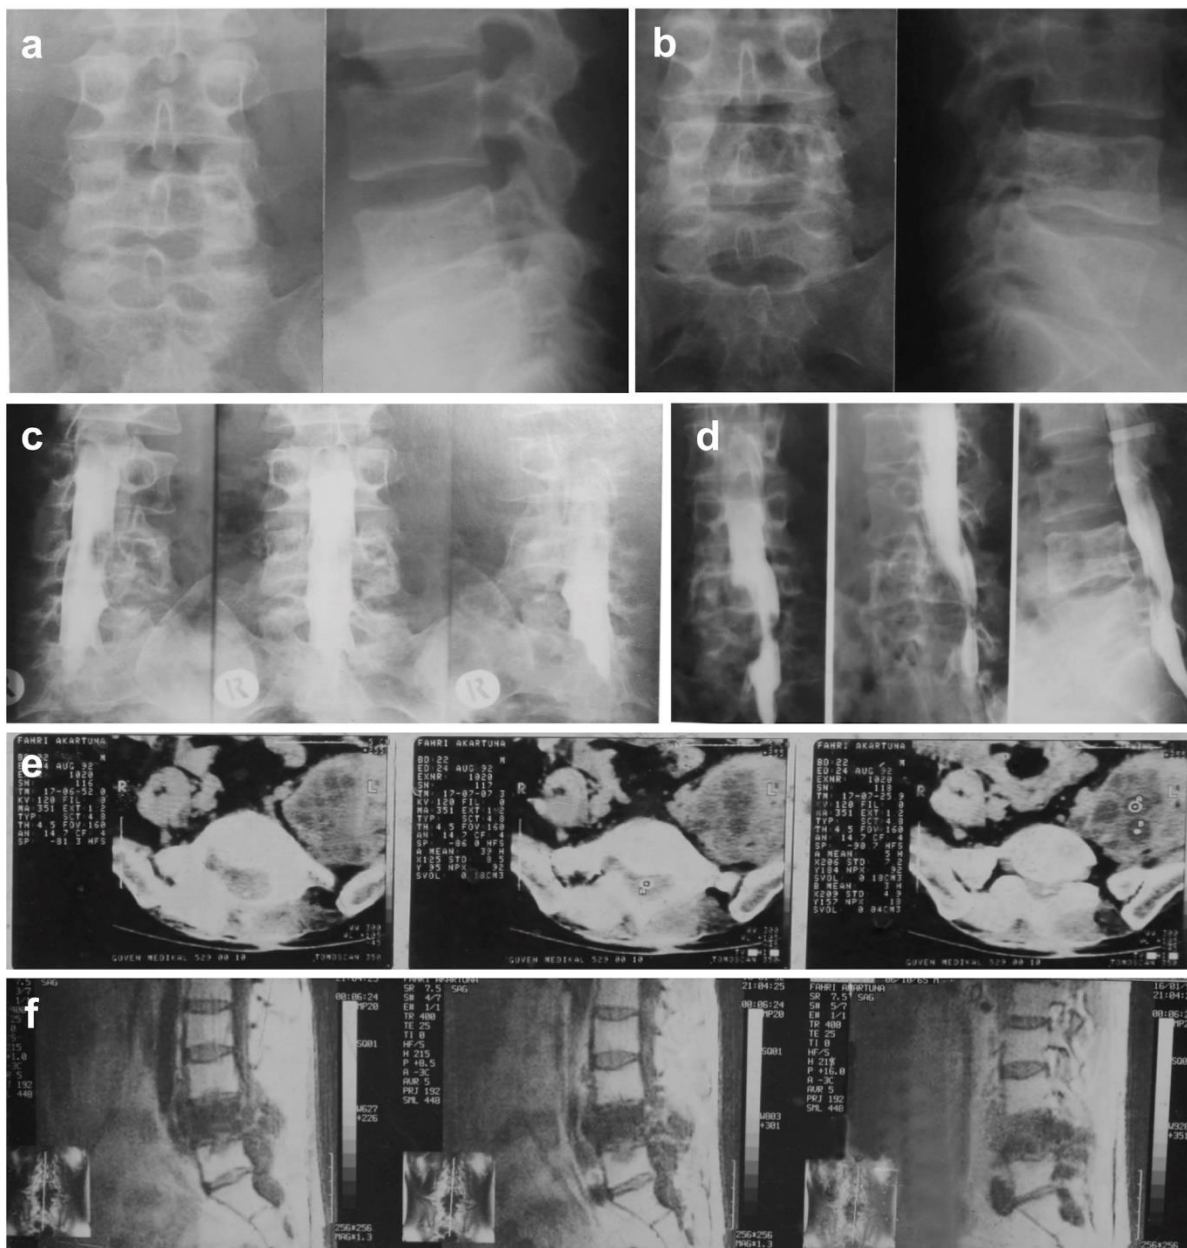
Preoperative X-ray (a, b), myelography (c, d), CT (e), and MR images (f) of a 36-year-old male patient with a spinal hydatid cyst.
